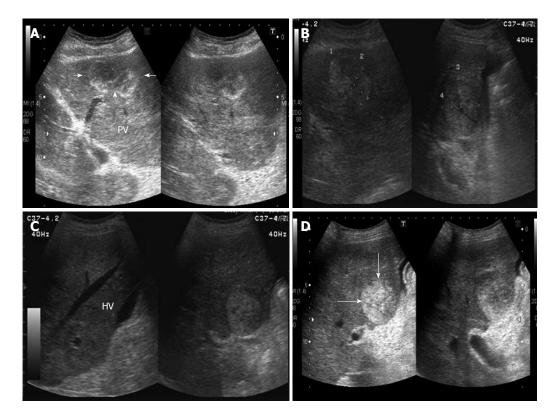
Abdominal ultrasound showing multiple hyperechoic or mixed echoic tumors in the bilateral lobes of liver (arrows). Minimal ascites was also detected. A: One mixed echoic tumor (arrows) at segment 3, left portal vein (PV); B: One mixed echoic tumor (marked) at segment 5; C: One hyperechoic tumor at segment 5, right hepatic vein (HV), minimal ascites also detected; D: One hyperechoic tumor (arrows) at segment 5 near the main portal trunk.
